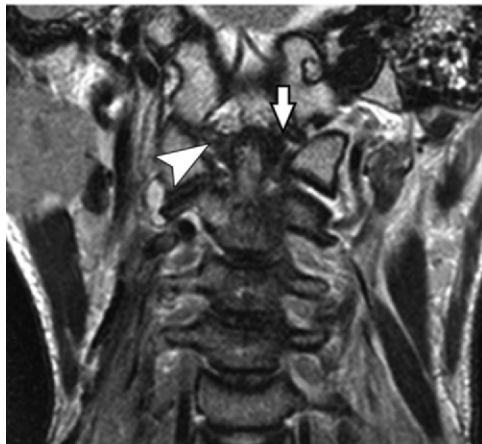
Anderson and Monsanto type III occipital condyle fracture. (a) Coronal reformatted CT image shows an avulsion fragment of the left occipital condyle (arrow), compatible with a type III fracture. (b) Coronal T2-weighted MR image shows avulsion of the left alar ligament (arrow). There is also increased T2 signal in the right alar ligament (arrowhead). (c) Axial T2-weighted MR image shows a tear in the left side of the transverse ligament (arrow).
